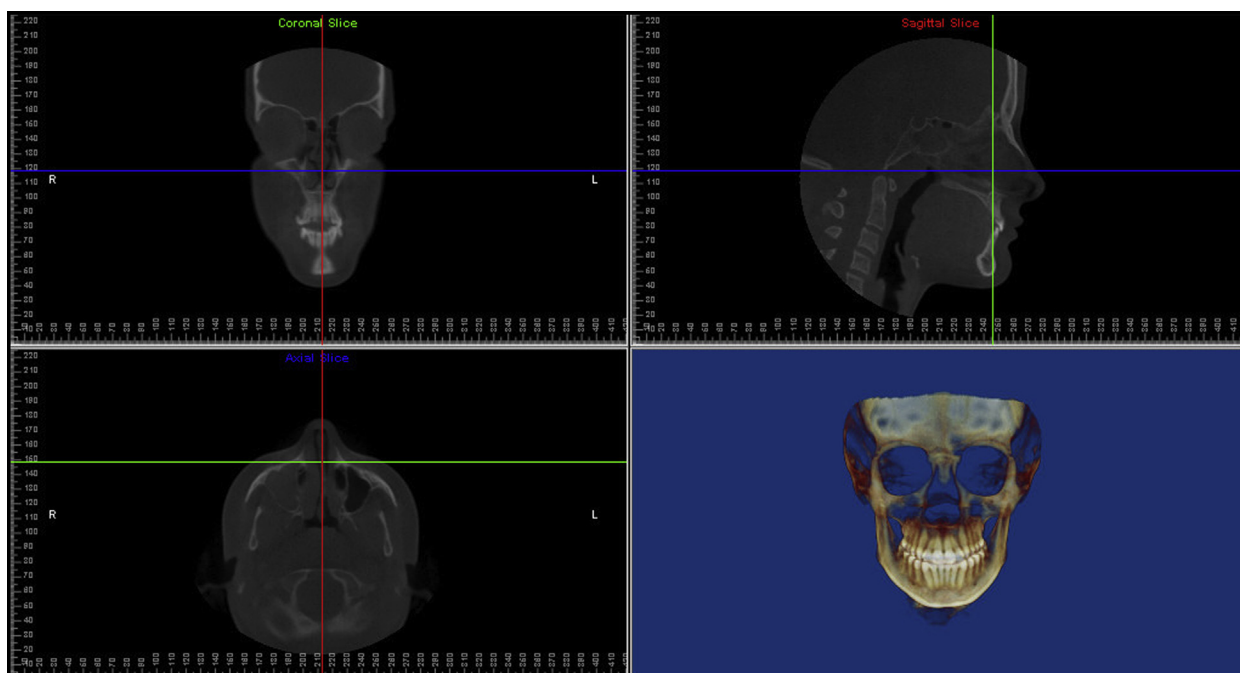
CBCT orientation: orient the subject in the coronal view so that the axial plane is aligned with the optic foramen, and in the axial view so that the coronal plane is aligned with the left and right foramen ovale. Orientation of the sagittal plane with foramen cecum in the coronal view and the axial plane with McRae's line in the sagittal view.
